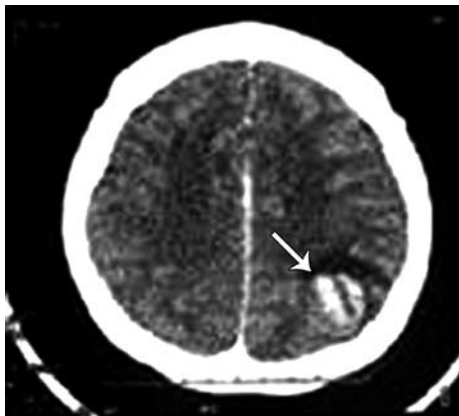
The CT scan of the brain reveals left fronto-parietal hemorrhagic infarct.
